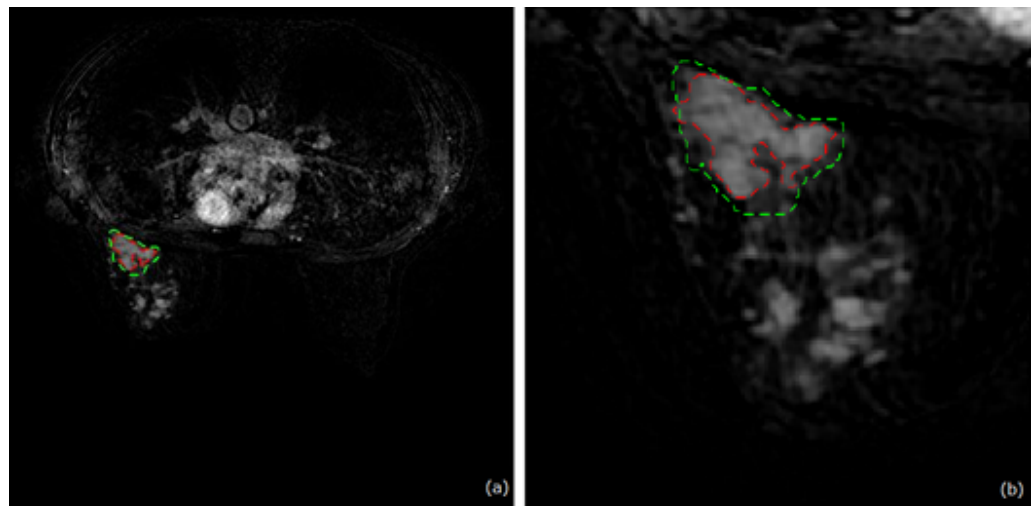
Case with a blurred boundary lesion: (a) entire axial DCE-MRI slice; (b) crop of the slice shown in (a). Comparison between manual ground-truth (green) and automated segmentation (red).
